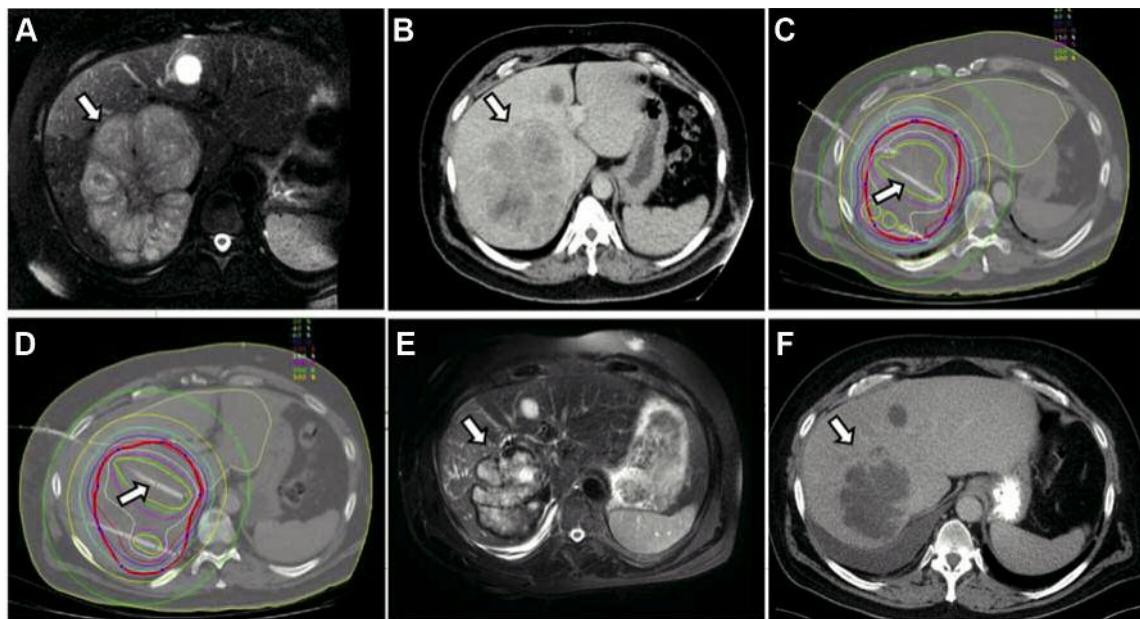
Local tumor control in a patient with metastatic renal cell carcinoma in the right liver lobe. A/B: T2w MRI and pre-interventional contrast-enhanced CT; white arrow shows a metastasis from renal cell carcinoma in the left liver lobe prior to treatment by interstitial brachytherapy. C/D: Planning CT with indicated CTV (red line), catheter (marked in red) and isodose lines. E/F: Follow up MRI (E) and CT (F) after 6 months: Size reduction of the previously treated lesion in the left liver lobe (white arrow).
